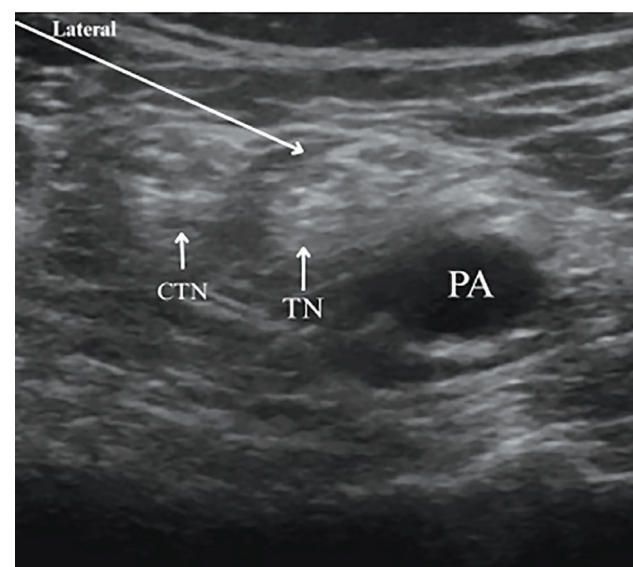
Ultrasound image of popliteal sciatic nerve block
